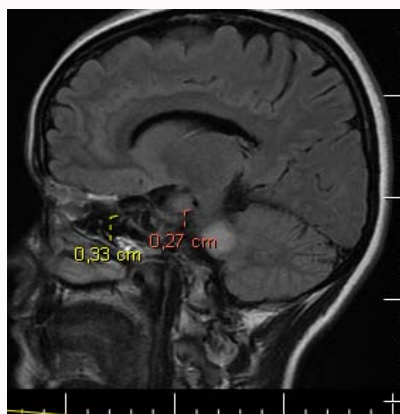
FLAIR-contrast-enhanced cranial MRI sequences dated 27/11/2019.
